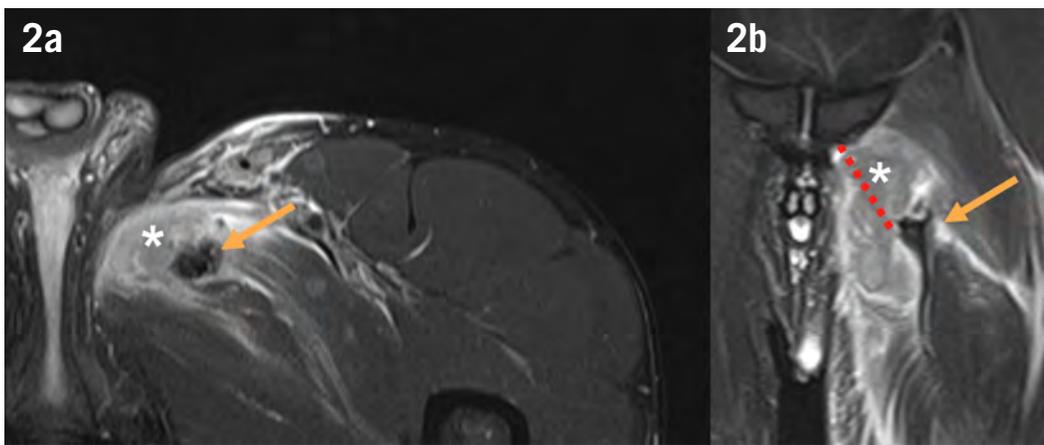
Magnetic resonance imaging of an adductor longus proximal tendon tear. Axial (a) and coronal (b) T2 weighted images with fat saturation show adductor tendon proximal avulsion with interposed heterogeneous hematoma (*) and distal retraction (dotted red line) of the tendon stump (yellow arrow). There is edema and fluid in the surrounding muscle and fat tissues due to infiltrative hematoma and local inflammation.
